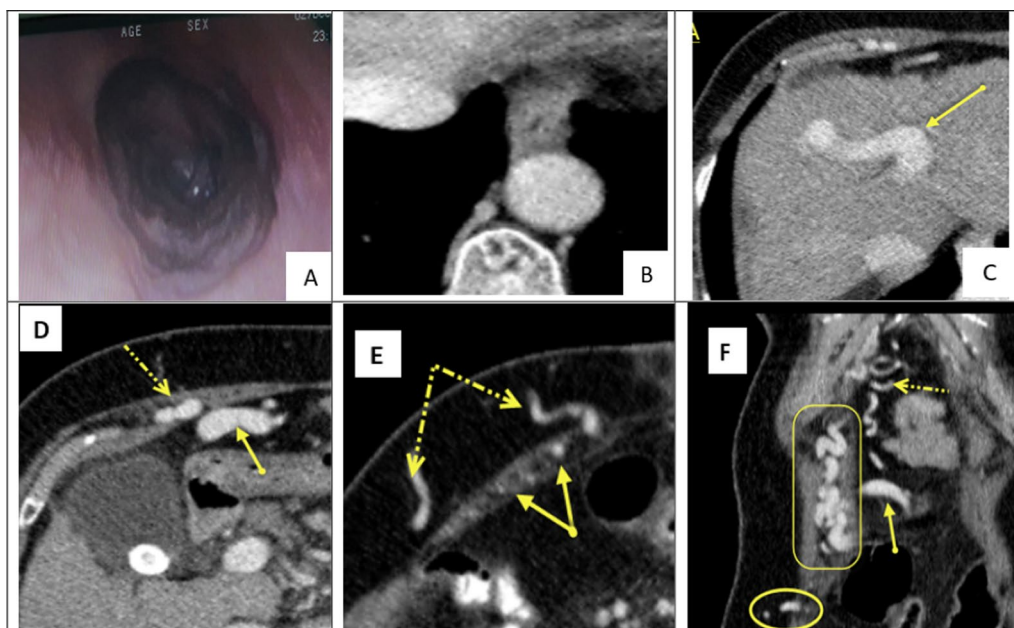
A 66-year-old male patient with chronic liver disease. To evaluate the patient's hepatofugal flow, a triphasic MDCT scan was performed in addition to US scanning. Upper GI endoscopy was also performed to screen for esophageal varices. A Upper gastrointestinal (GI) endoscopy and B axial computed tomography (CT) both demonstrated the absence of esophageal varices. Also, axial CT revealed; C, D left hepatic shunt (solid arrow), right rectus intramuscular varices (dashed arrow), E right rectus intramuscular varices (solid arrow), as well as subcutaneous varices (dashed arrow). F Coronal CT demonstrated a right hepatic shunt (solid arrow), a paraumbilical vein (dashed arrow), right rectus intramuscular varices (rectangular region), and subcutaneous varices (round region)
